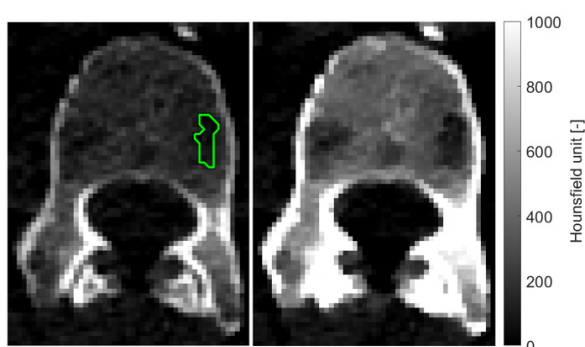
Example of the first lumbar vertebra with the lytic lesion (green contour) on conventional CT (left) and VMI at 40 keV (right).
